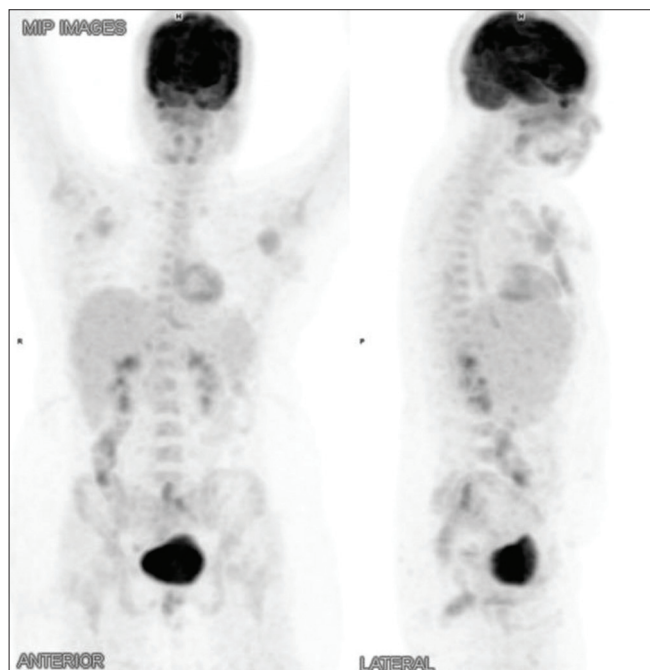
Maximum intensity projection of 18-fluorodeoxyglucose positron emission tomography/computed tomography scan showing abnormal increased tracer uptake in the sinuses, breasts, retrosternal, and sacral region
